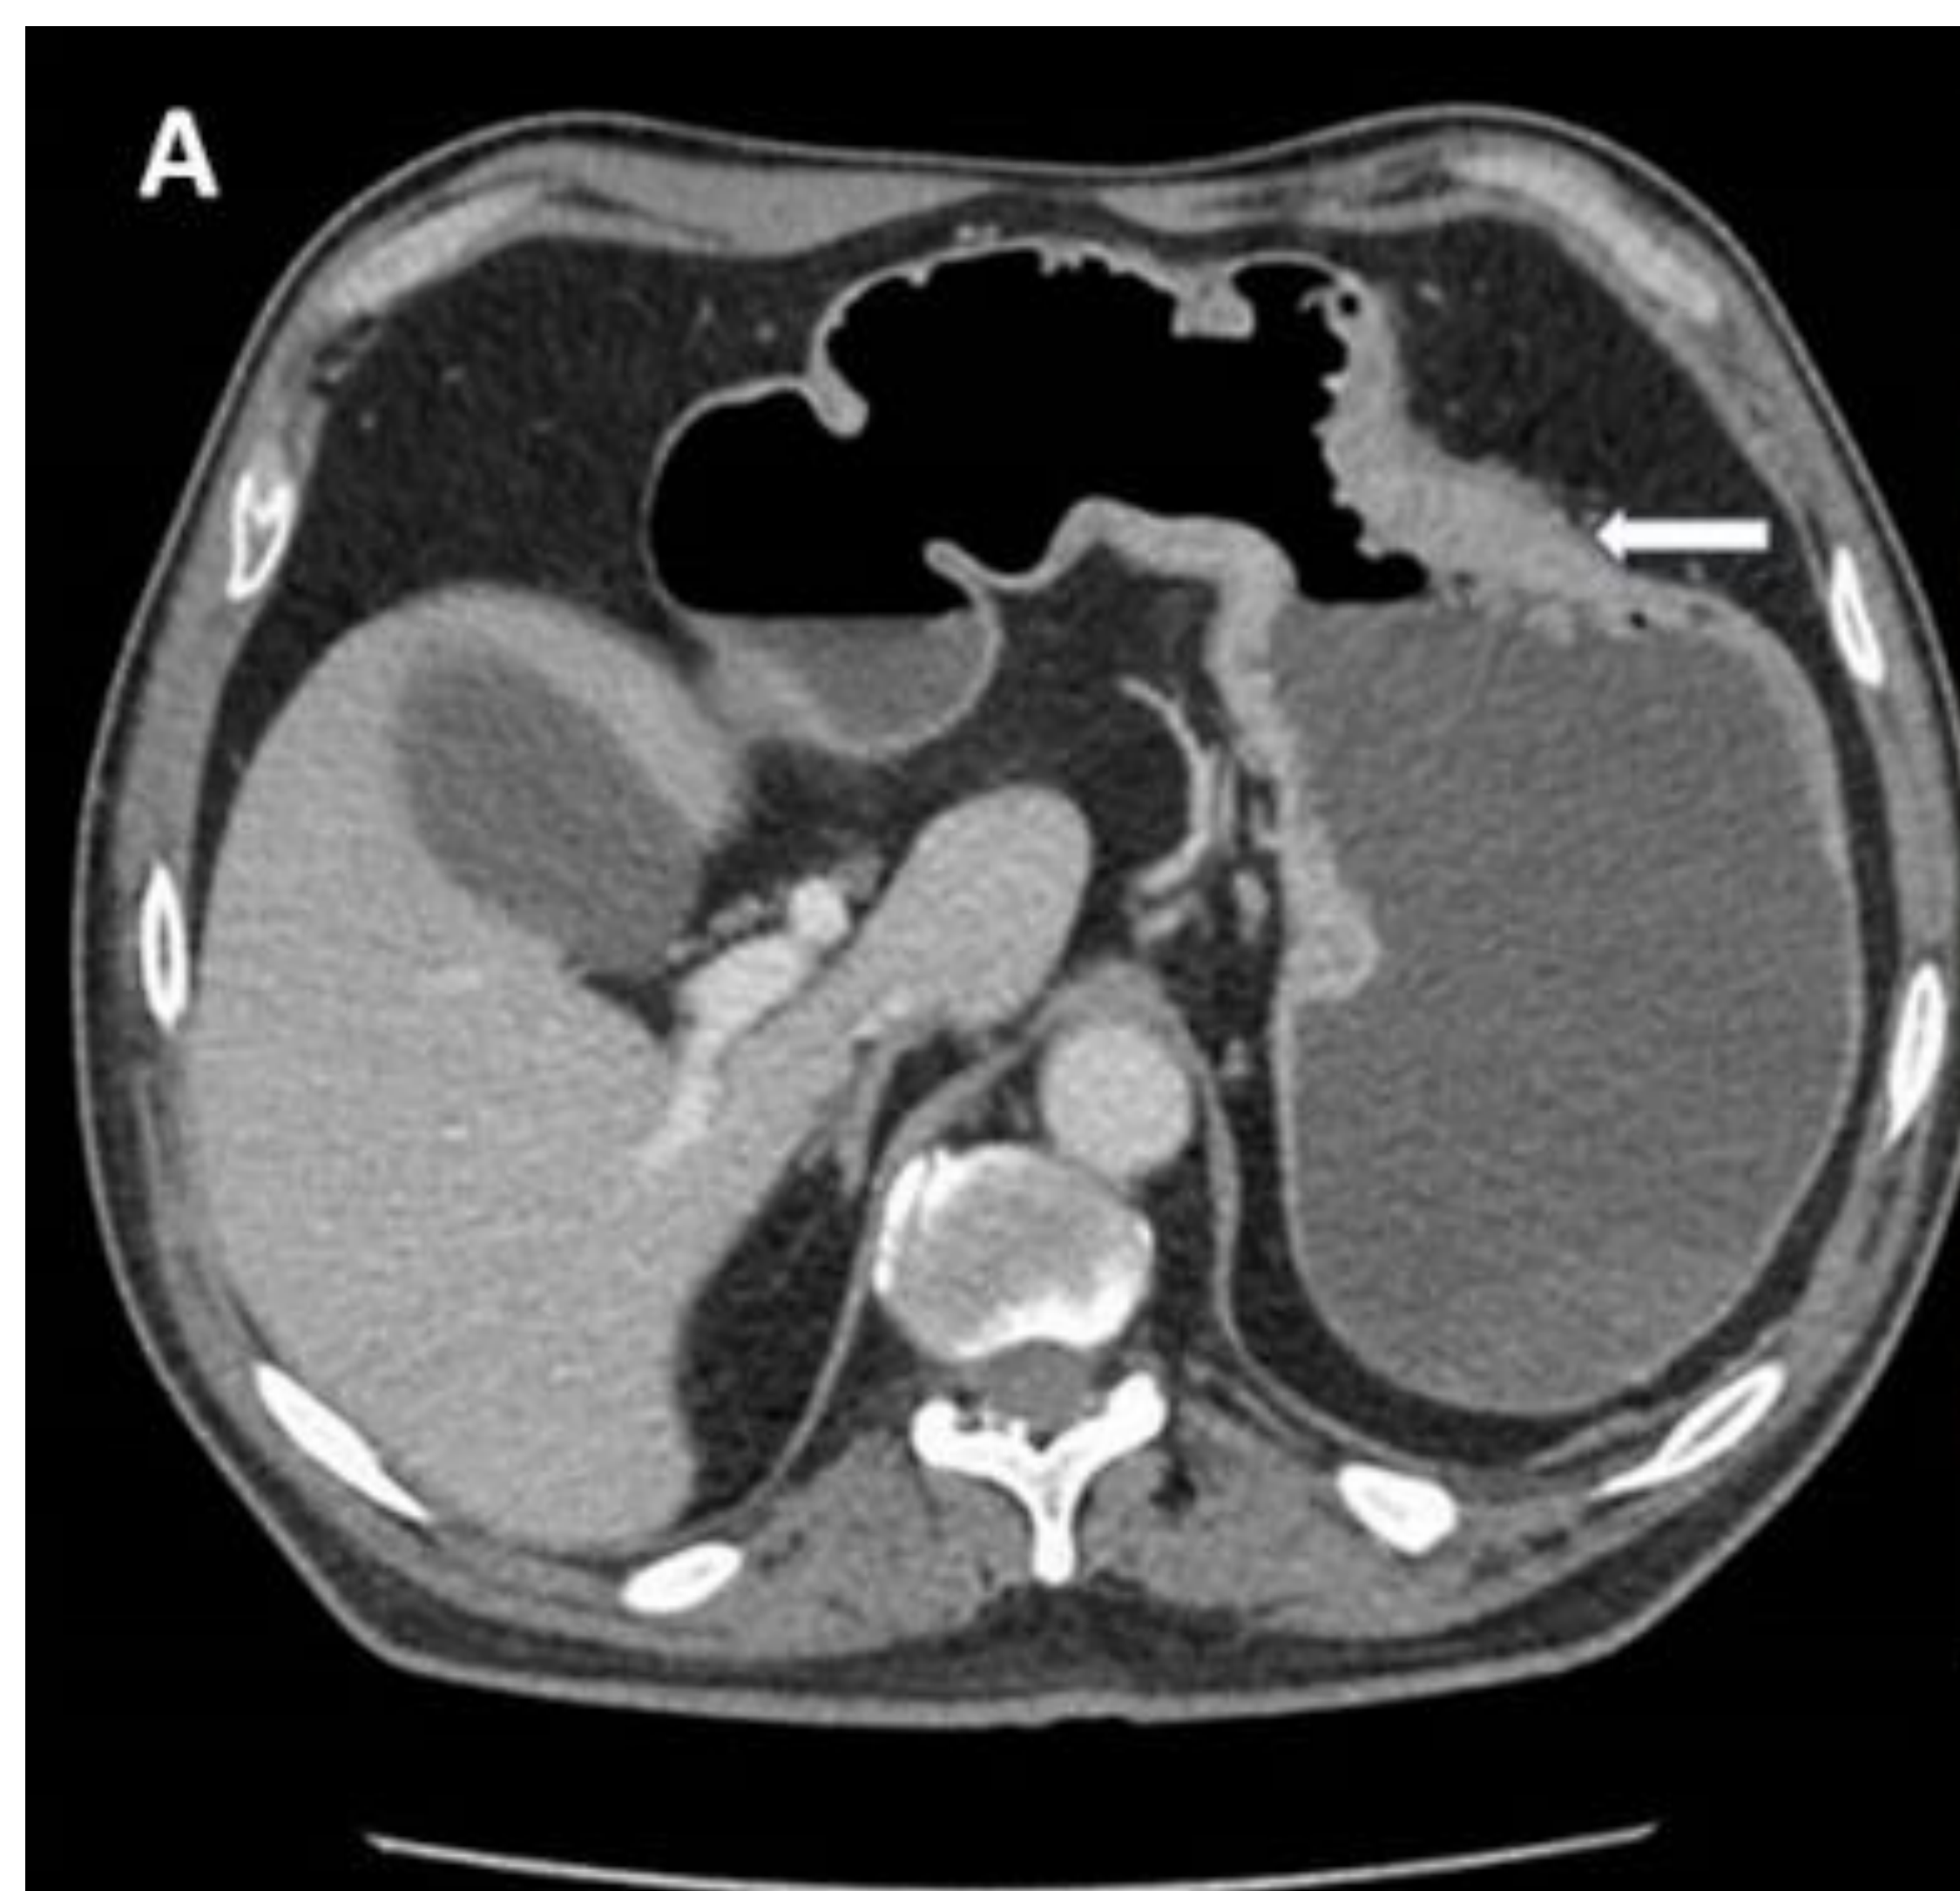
(A): CT abdomen with dilated stomach and duodenum with decompressed distal small intestine (arrow)
